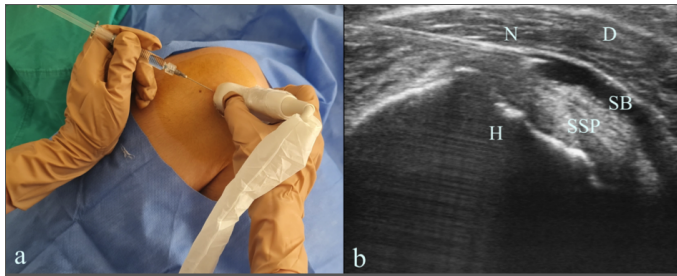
The position of the patient and the probe (a), who underwent subacromial injection with ultrasound guidance, sonographic view of the needle in the subacromial bursa (b)
